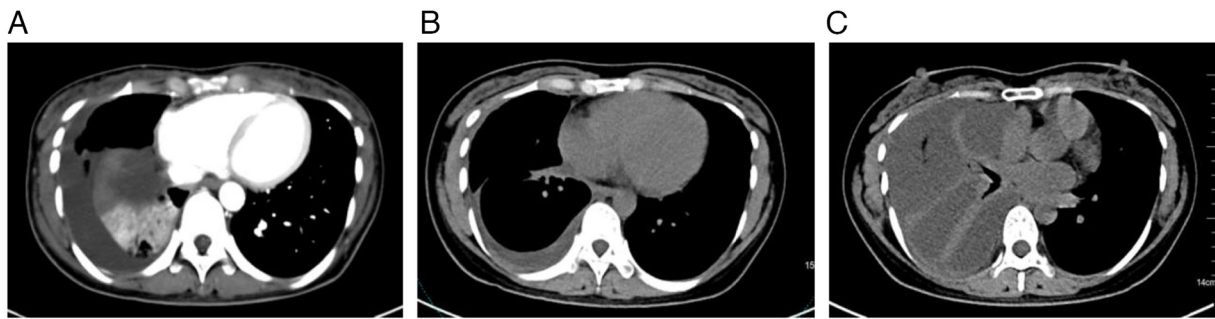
Imaging examination results of the disease course. (A) Baseline CT (August 2023): Mass shadow at hilum of lung, atelectasis of lower lobe of right lung, moderate effusion in right chest cavity. (B) After 8 months CT (April 2024): The mass shadow near the hilum of the right lung, the focus was markedly smaller compared with that at baseline. The multiple small nodules in the right lung were smaller compared with that at baseline and the inflammation of both lungs was basically absorbed. The right pleural thickening, pleural effusion, markedly improved compared with that at baseline. (C) CT at 1 year later (August 2024): Atelectasis is progressing and there is a lot of effusion in the right chest. The right lung is not fully inflated and the right lung is newly inflamed.
